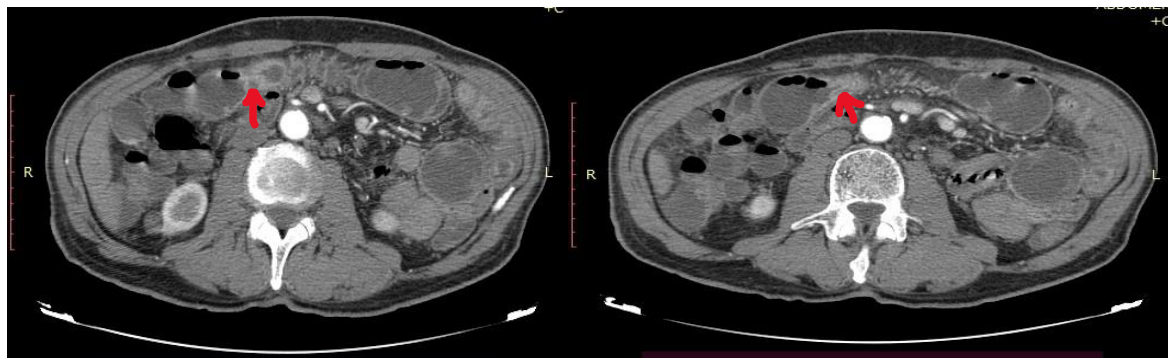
CT view of the tumor.
